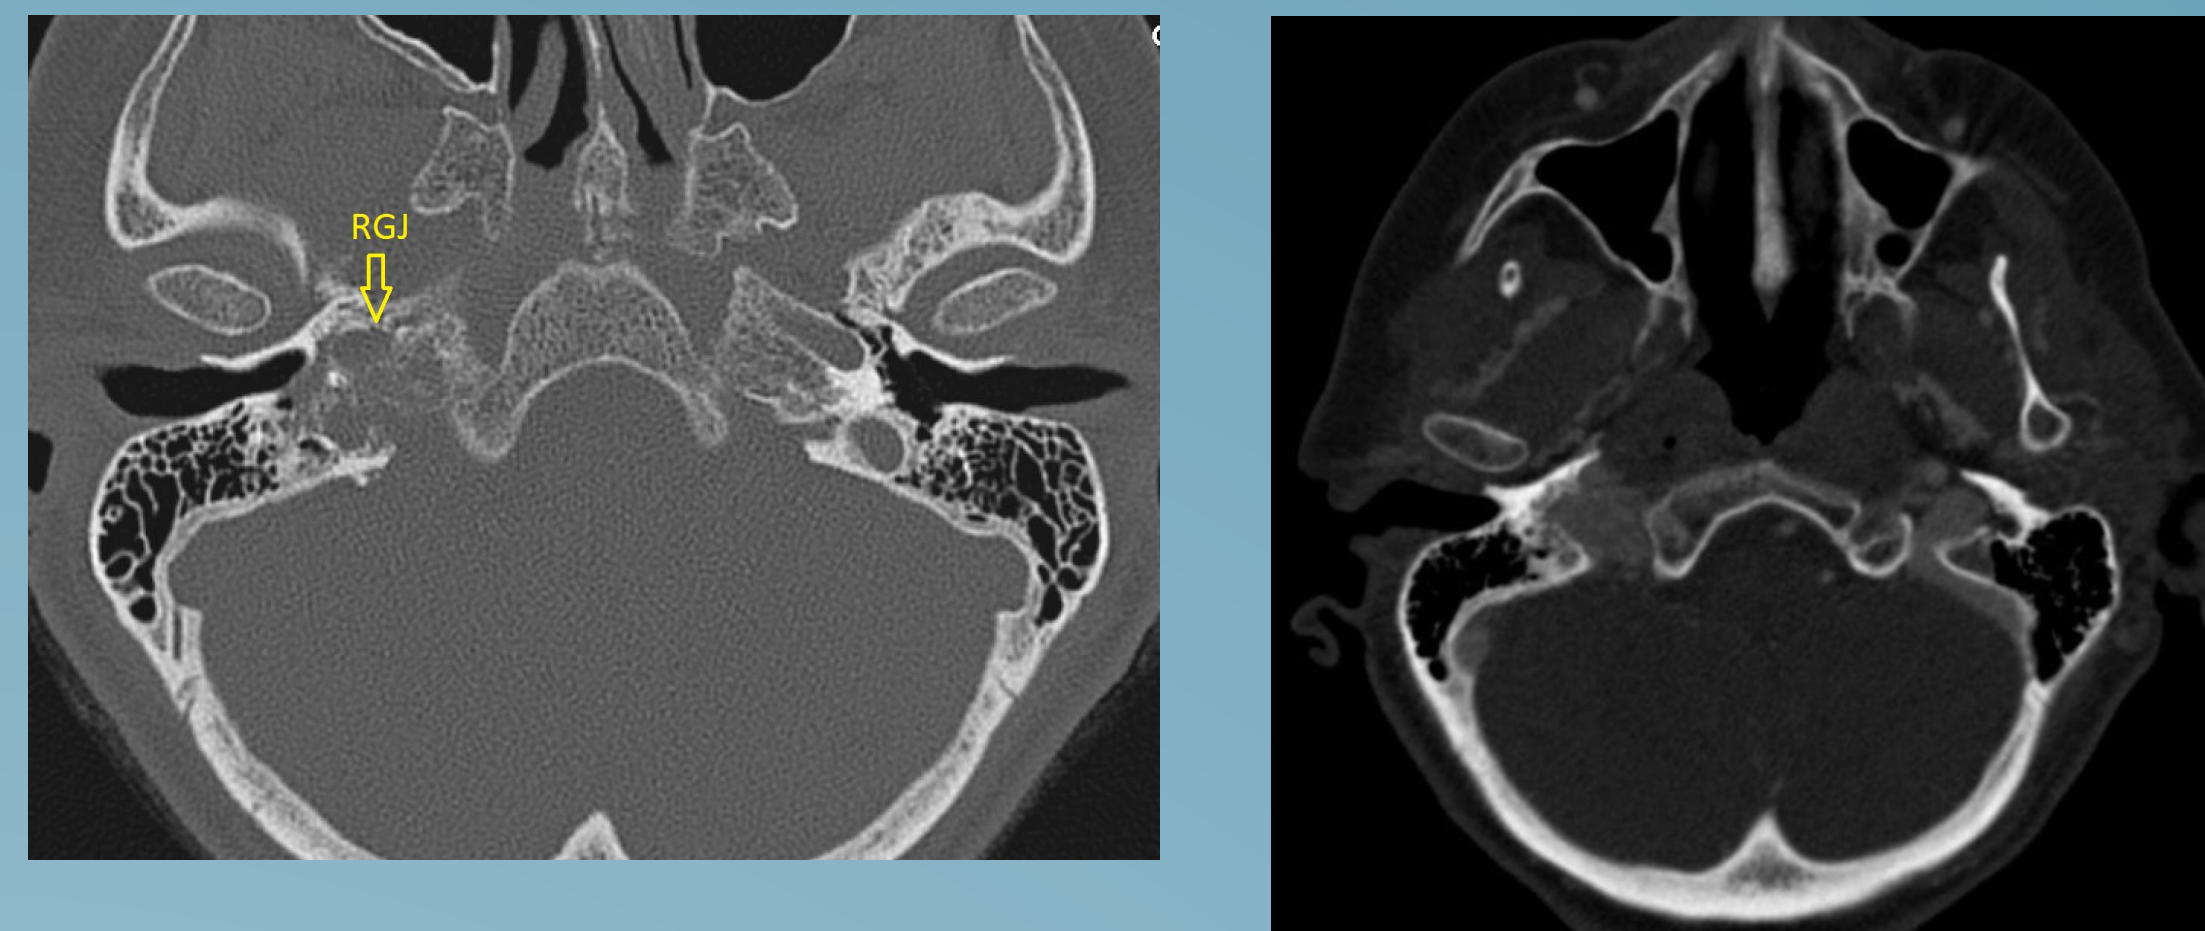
Axial CT temporal bone with contrast showing right glomus jugulare (RGJ) with classic irregular erosion and "moth eaten" appearance to temporal bone with extension to lower right CP angle and extending superolaterally towards hypotympanic region with erosive changes in jugular bulb.
